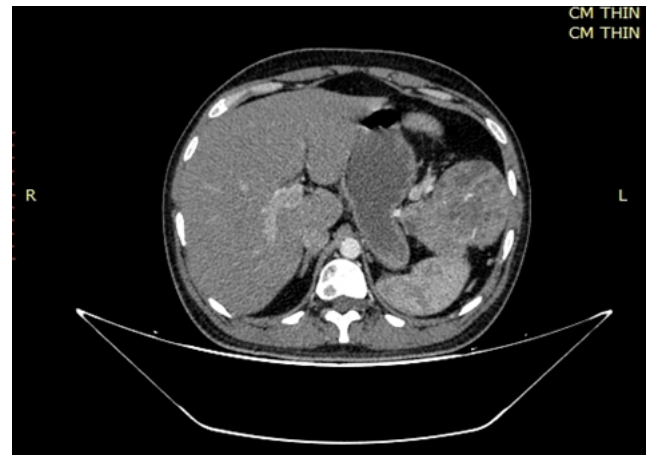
CT scan of case 1 show large, irregular heterogeneously enhancing lesion replacing entire kidney
